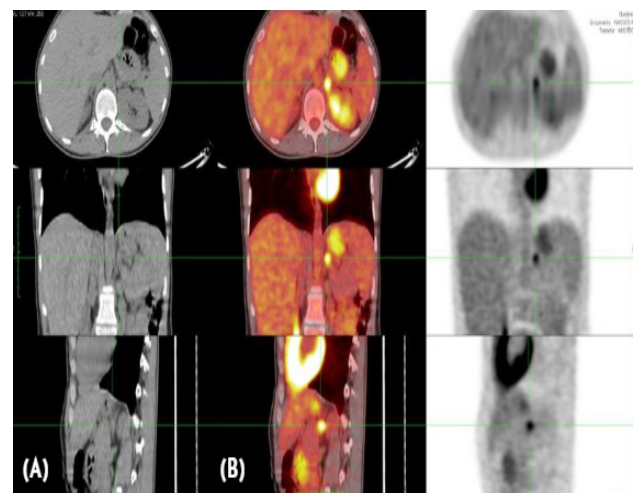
Initial PET/CT findings.
